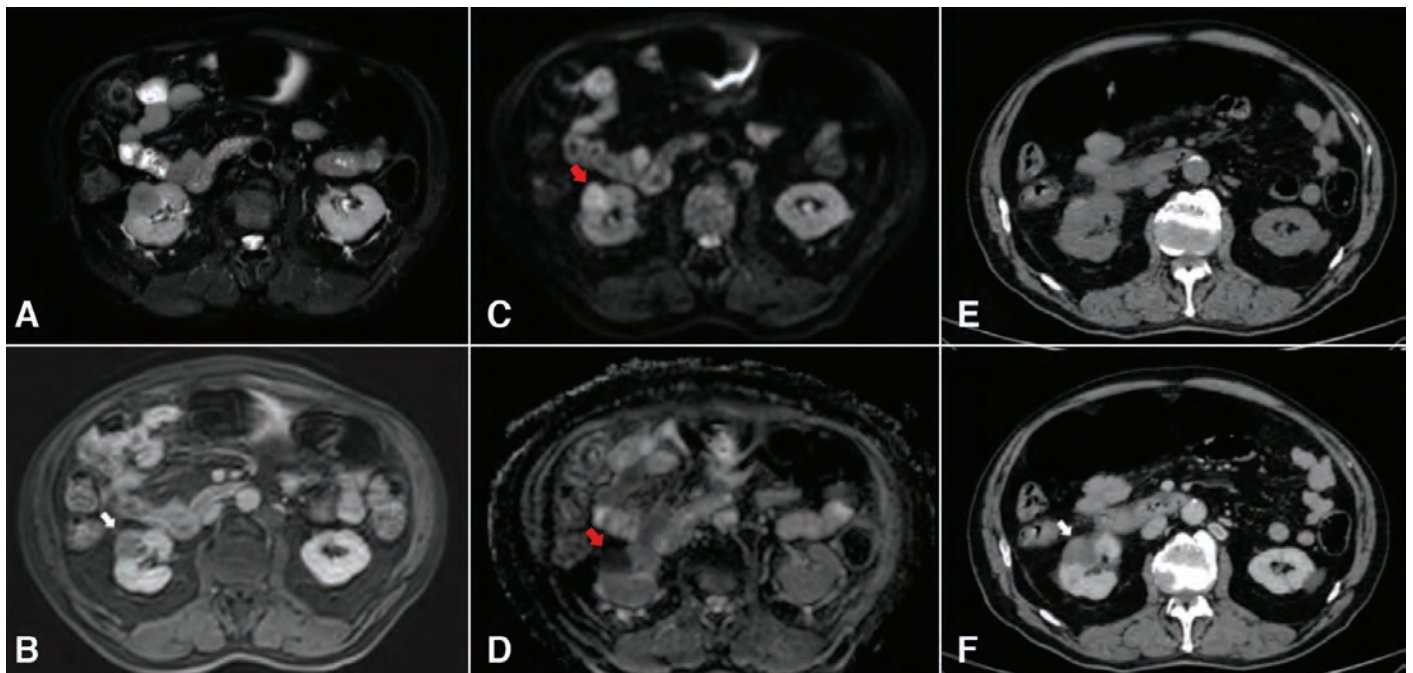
Contrast enhanced (CE) magnetic resonance (MR) images before the procedure (A-D) and follow-up CE computed tomography (CT) images (E, F). Well-demarcated SRM that was showing peripheral contrast enhancement and exophytic parenchymal localization in the right kidney (white arrow in B). The lesion showed diffusion restriction in diffusion weighted MR images (red arrows in C and D). In her first month follow-up, CE CT images demonstrated the ablation zone with no evidence of a residual tumor, compatible the complete ablation (white arrow in F)
